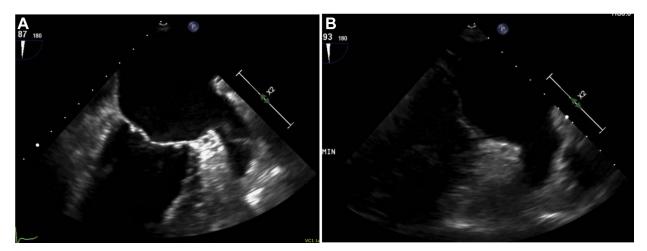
Transesophageal echocardiograms. A: The initial image with a left atrial appendage thrombus. B: Image after 5 minutes of isoproterenol infusion demonstrating the thrombus had resolved.
